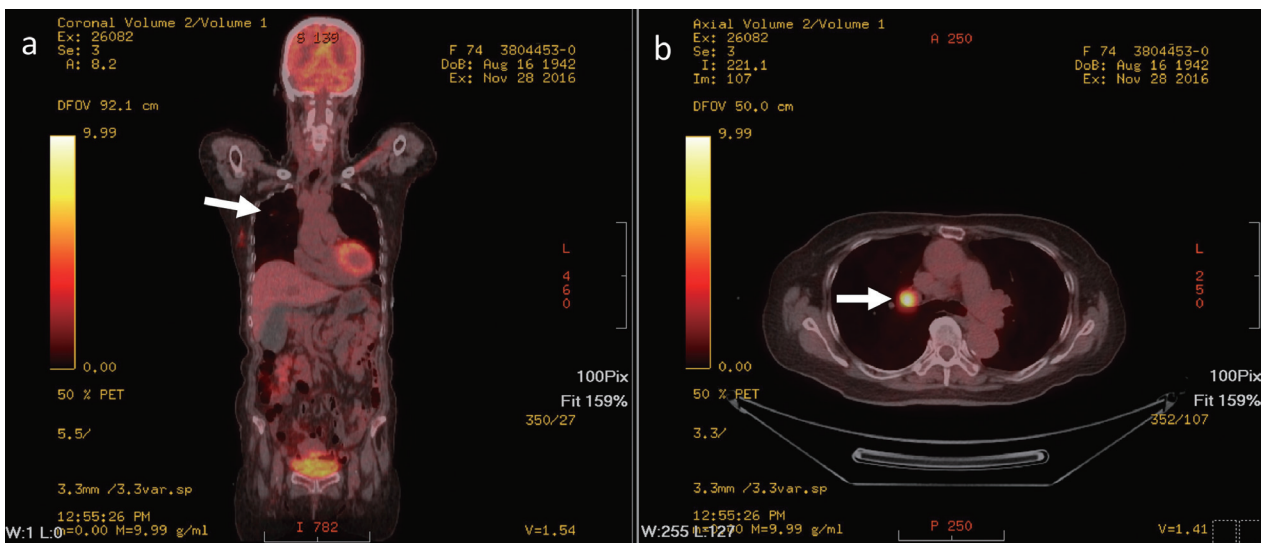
Whole body PET/CT showed a 7 mm nodular lesion in the RUL (a) and an enlarged lymph node around 1.8 cm at station 10R (b).
